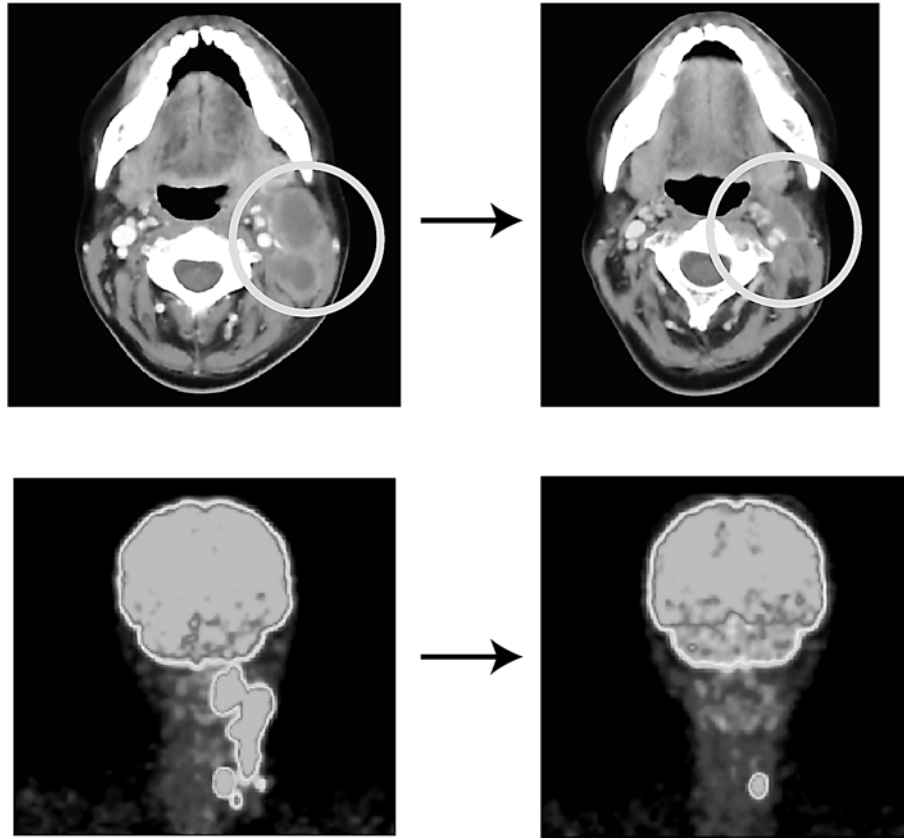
Computed tomography and positron emission tomography images before and after treatment. Computed tomography and positron emission tomography revealed resolution of the tonsil swelling and cervical lymphadenopathy. There was a left thyroid mass before hematopoietic stem cell transplantation and cytological analysis revealed a benign disorder.
